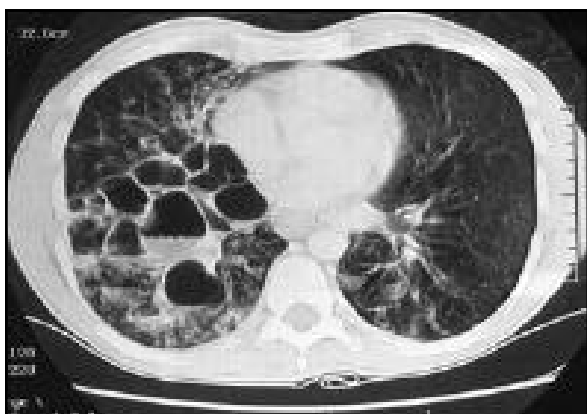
Chest CT showing bronchiectasis of both lower lobes of the lungs, more severe on the right side.
